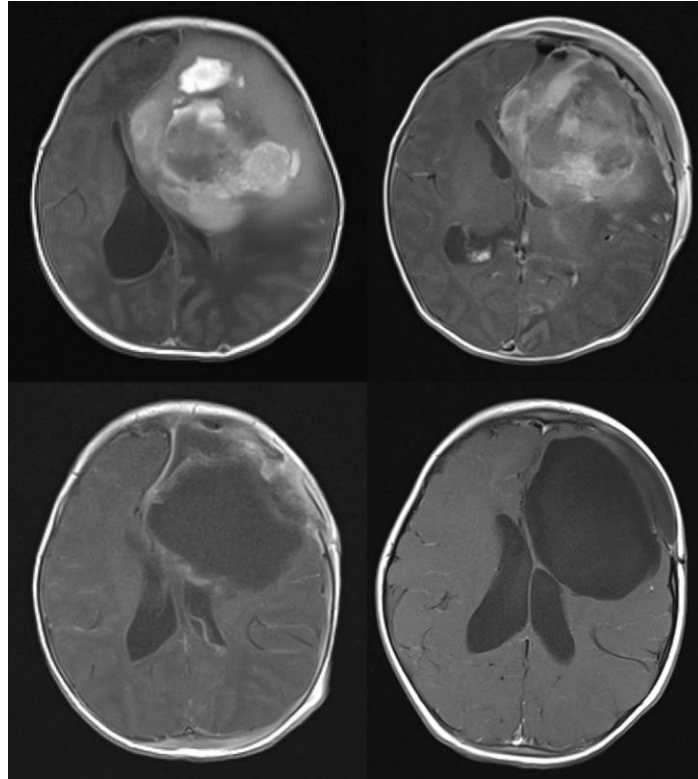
Infant girl with large left frontal high grade glioma diagnosed on day 1 of life. The patient was initially managed surgically with an open biopsy followed by gross total resection. She then underwent 2 cycles of chemotherapy on a modified HIT-SKK protocol<sup>30</sup> involving cyclophosphamide, vincristine, carboplatin, etoposide and methotrexate. A, pre-operative axial T2-weighted MRI. B, post-biopsy scan with some relief of mass effect. C, post-resection scan, consistent with gross total resection. D, 2 year follow up scan showing no tumor recurrence. All scans axial T1-weighted post-Gadolinium MRI.
